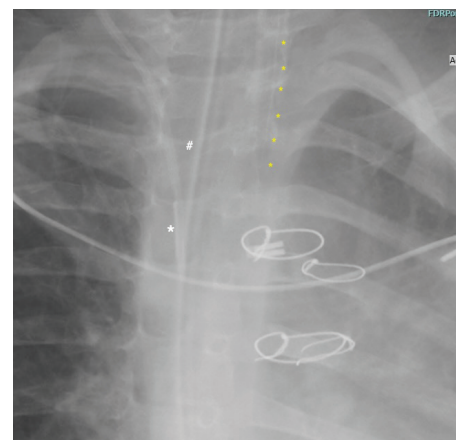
Radiopaque markers. This magnified image of a postoperative chest x-ray in a child following cardiac surgery was read by radiology as extubated due to the faint markers on this brand of endotracheal tube. White * - central venous line; White # - gastric tube; Yellow • - the endotracheal tube marker
